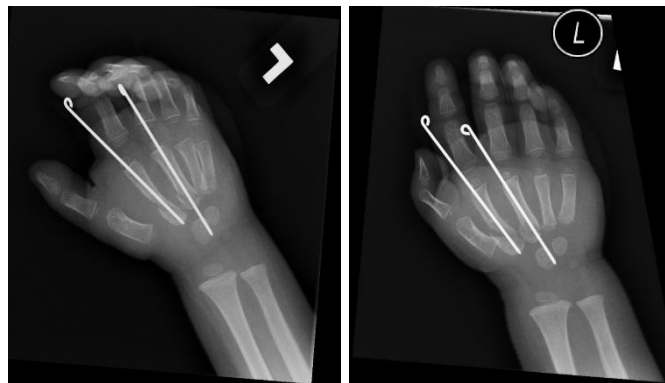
X-ray image at 2-weeks post-operation, showing the position of K wires and the fracture fixation
